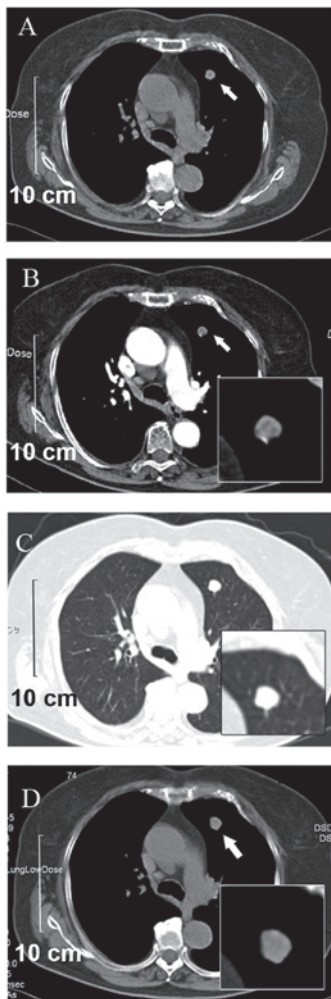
(A) CT of the chest revealed a round non-homogeneous parenchymal neoformation (arrow) that was ~1.2 cm in diameter and located in the anterior segment of the left upper lobe of the lung. The lesion was sharply demarcated. (B) The contrast-enhanced CT revealed minimal contrast-enhanced areas, and the lesion did not include any calcifications or fat. There was no sign of lobation and speculation. Neither the mediastinal nor hilar lymph nodes were observed to be enlarged in the (B) mediastinal and (C) pulmonary windows. CT, computed tomography.
